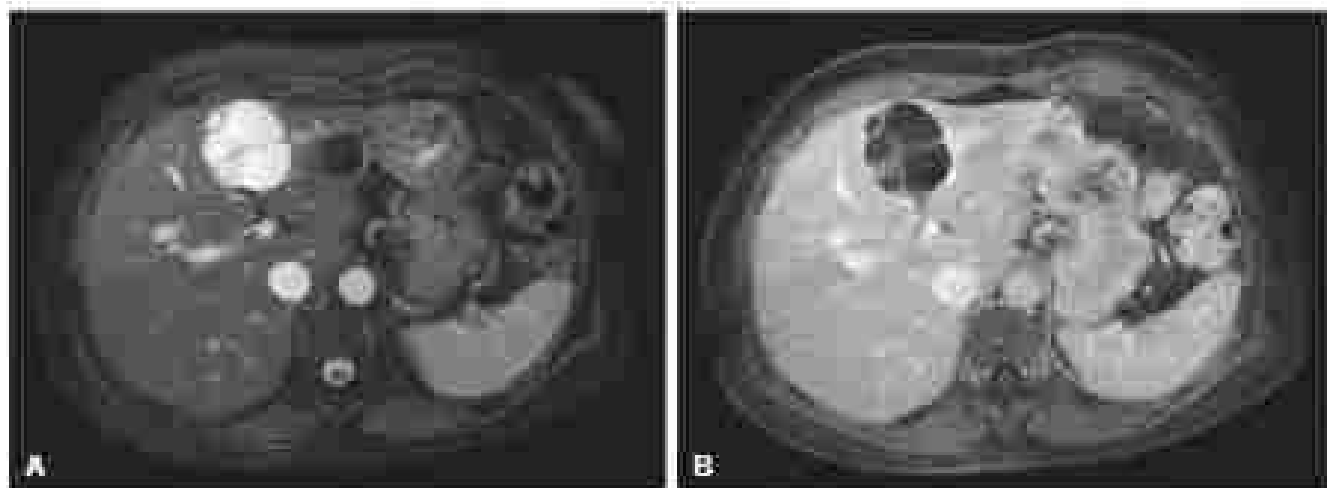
(A) Axial T1-weighted image demonstrating a cystic lesion in the left lobe of the liver in a 57-year-old woman. (B) Axial T1-weighted imaging of the same lesion reveals a hypointense, ringed rim with dark borders.
